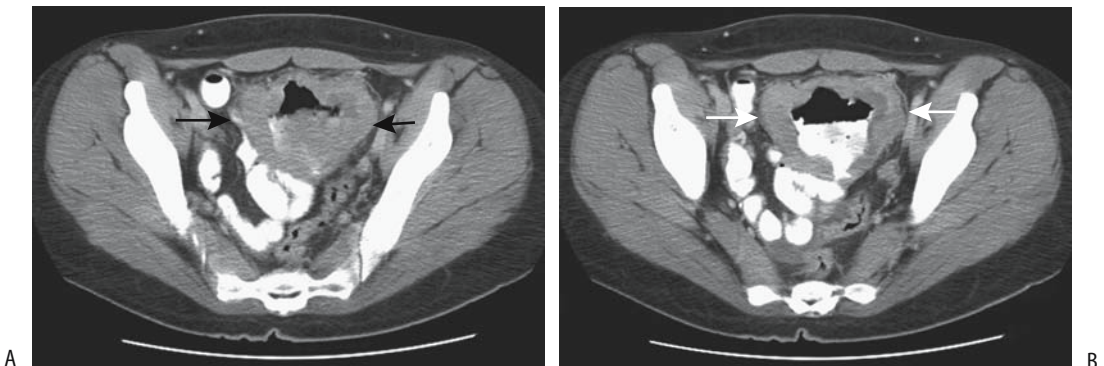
Non-Hodgkin's lymphoma. A,B: Two CT images reveal a tumor (arrows) with a necrotic center (arrowheads). No bowel obstruction was present.
